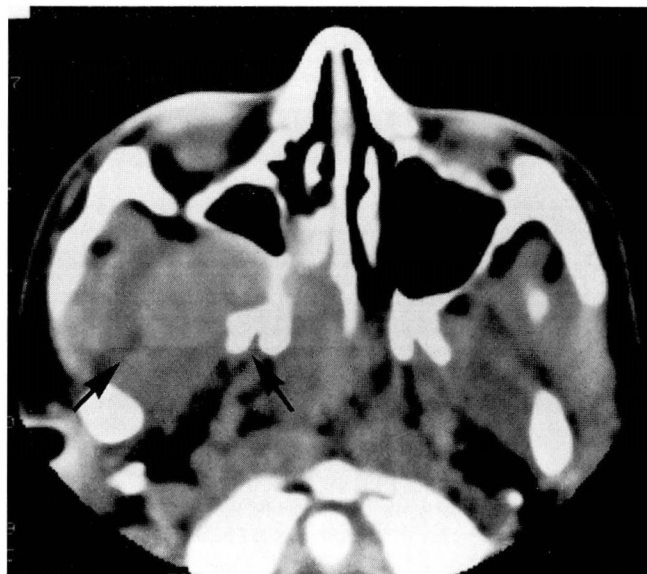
Computed tomogram of the nose and paranasal sinuses showing right-sided angiofibroma (on left side of figure). Note mass in right side of nose, nasopharynx, and pterygopalatine fossa, as well as anterior bowing of posterior wall of right maxillary sinus and erosion of anterior aspect of pterygoid plates on right.
